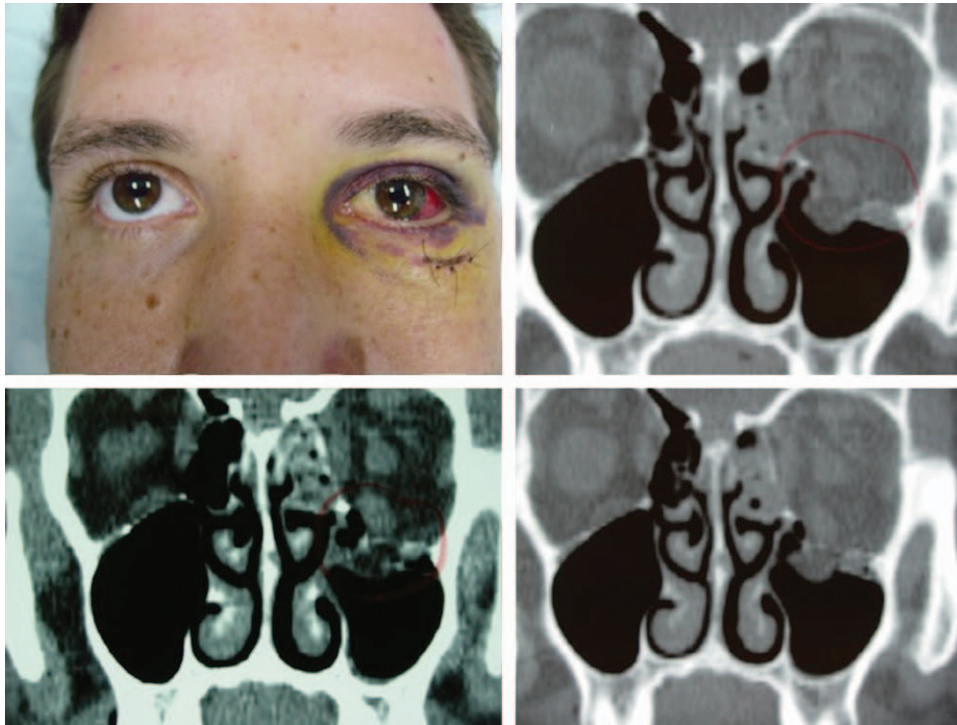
Orbital floor blowout fracture caused by direct trauma from opposing player's elbow. Clinical appearance and CT showing herniation of orbital fat in the maxillary sinus. CT indicates computed tomography.
